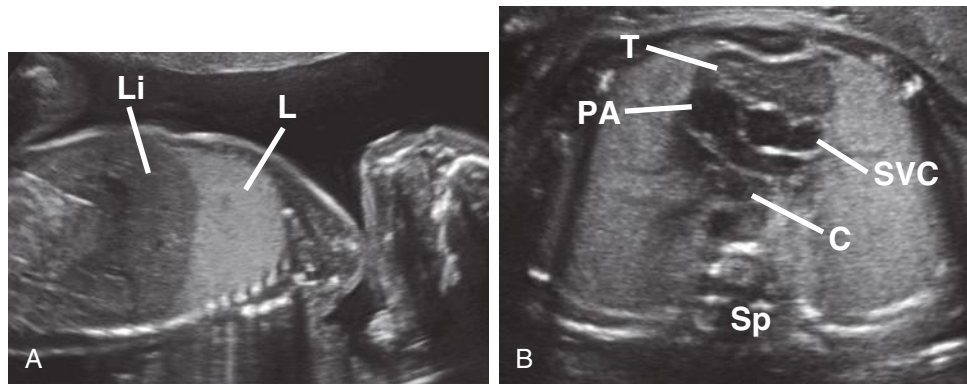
A, Sagittal sonogram through the fetal chest. Echogenicity differences between lung (L) and liver (Li) are easily seen in this older fetus. B, Axial sonogram through the fetal chest. Again, the echogenicity differences between the lung and thymus (T) are easily seen. C, carina; PA, pulmonary artery; Sp, spine; SVC, superior vena cava.
